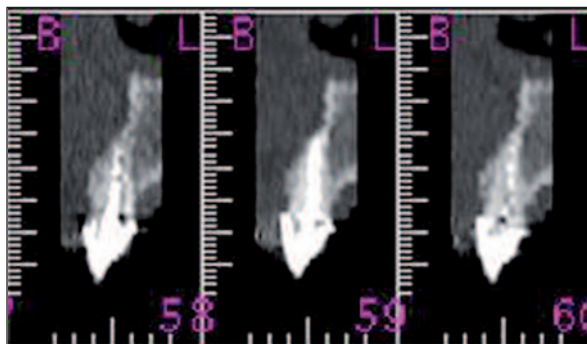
The view of the maxilla obtained from computerized tomography after five years (Siemens Somatom Plus4, Dental CT Programme). (see for colored form <http://dishekimligi.turkiyeklinikleri.com/>)
